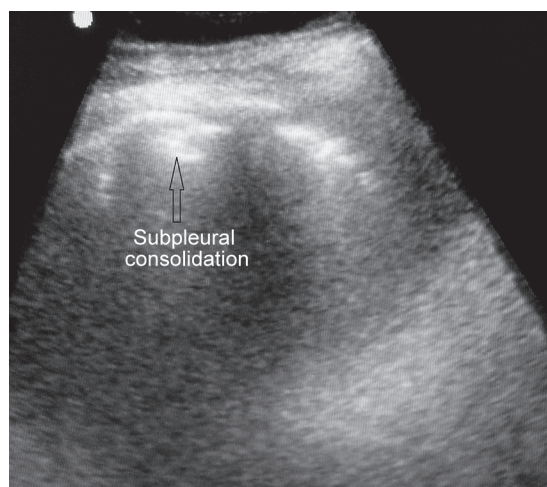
Lung ultrasound showing subpleural consolidation
